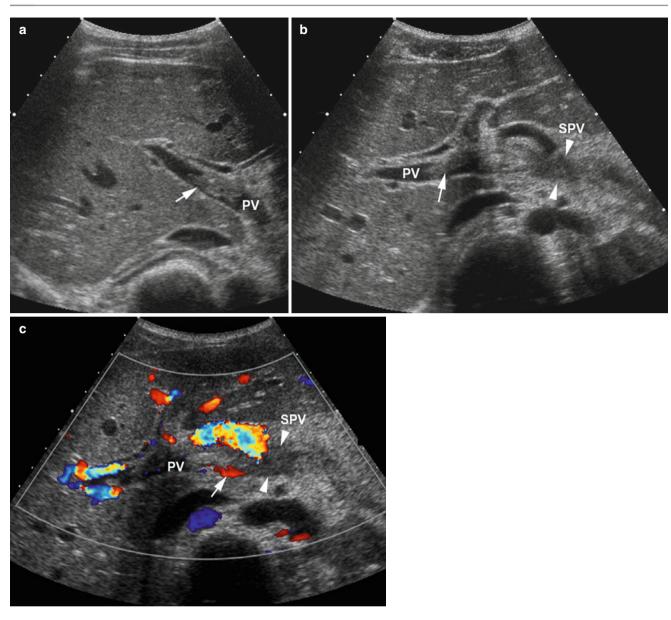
Portal vein partial thrombosis. (a) Sonogram of porta hepatis demonstrating thrombus (*arrow*) partially obstructing the portal vein (*PV*). (b) Sonogram of same patient showing thrombus filling the splenic vein (*SPV*, *arrowheads*) and partially filling the portal vein (*PV*)
